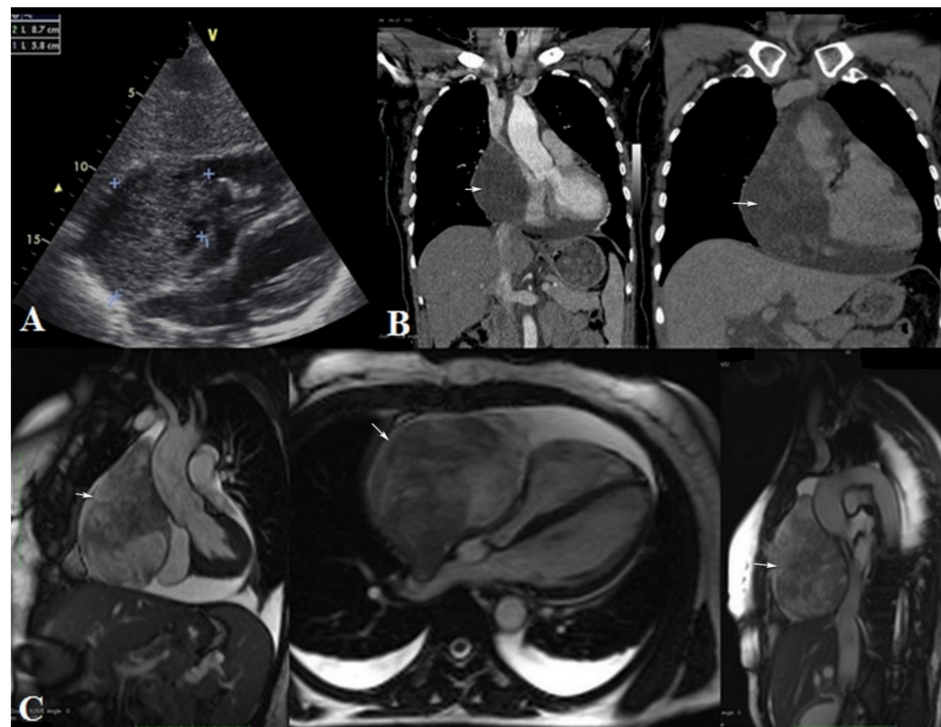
(A): Echocardiography; (B): computer tomography with contrast enhancement—coronal plane; (C): MRI—coronal, axial and sagittal T2 WI; There is a large, inhomogeneous, enhancing intrapericardial mass, surrounded by fluid, with marked compressive effect on the superior vena cava and right heart cavities (arrows). No intracavitary or endoluminal invasive aspects are present.
